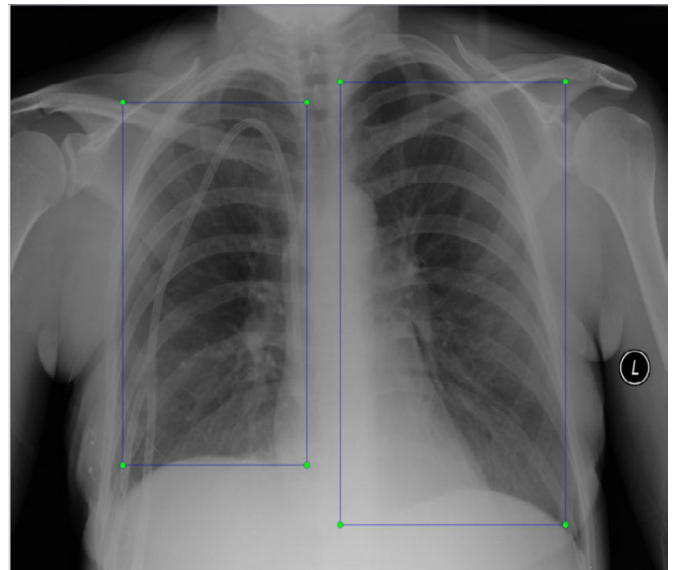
Created bounding boxes of normal regions in a chest X-Ray image.
